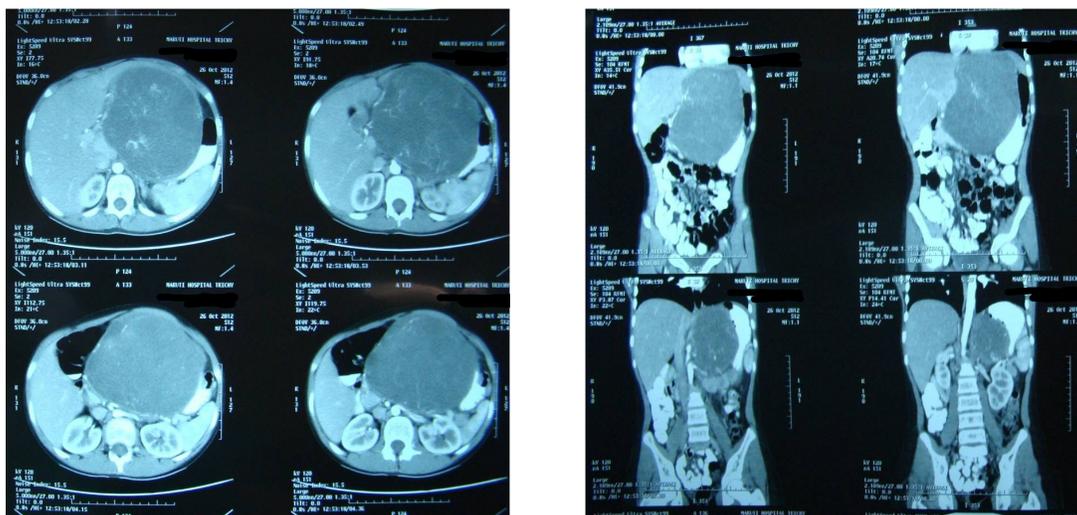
CT scan of upper abdomen (axial and coronal sections) showing homogeneously enhanced mass lesion of 14.9 x 12.9 cm in left lobe of liver, with multiple vascular structures traversing the lesion suggestive of hepatocellular carcinoma.
